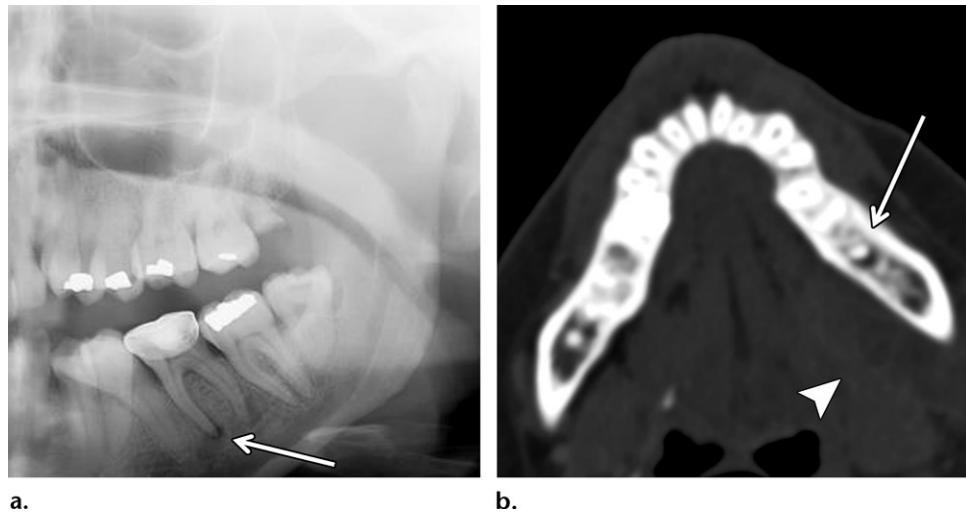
Periapical abscess of a mandibular molar in a 46-year-old woman who presented with left temporomandibular joint pain, difficulty opening her mouth, and altered mental status. (a) Radiograph shows a periapical lucency involving the mesial root of the left first mandibular molar (arrow). (b) Axial CT image (bone window) shows the periapical lucency (arrow), with soft-tissue stranding medial to the mandibular alveolar bone (arrowhead).
